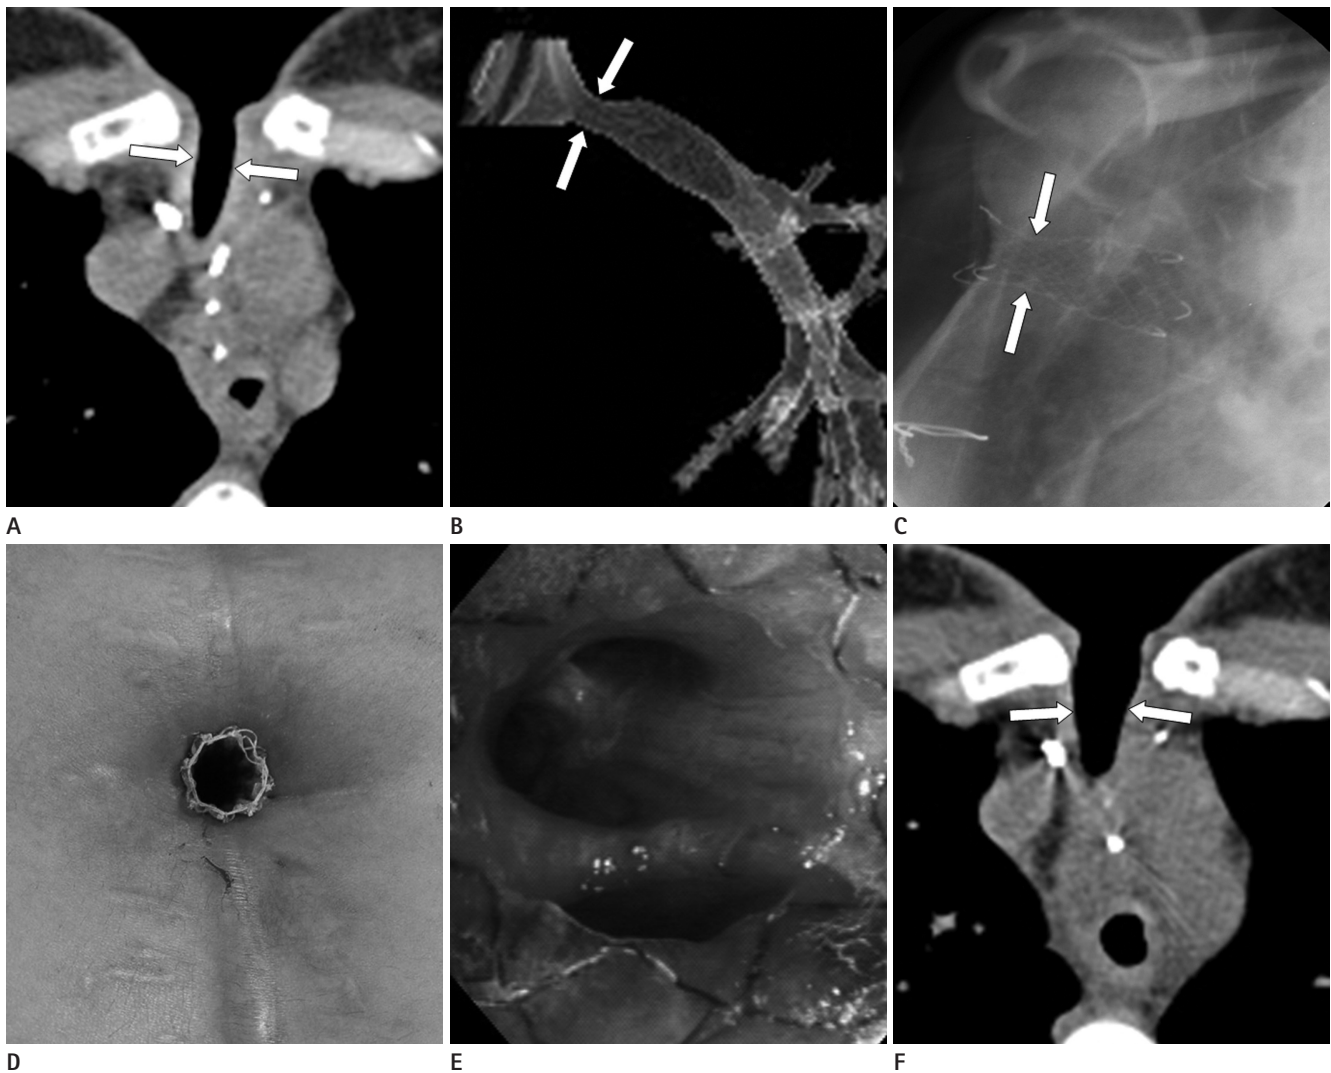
Temporary stent placement for the stricture of the stoma after anterior mediastinal tracheostomy for adenoid cystic carcinoma. A, B. Axial and reconstructed CT images show a tight stricture (arrows) at the ostium of the anterior mediastinal tracheostomy. C. A 12-mm-diameter, 3 cm-long, covered retrievable self-expandable nitinol stent was placed under fluoroscopic guidance to treat the stricture. There is a waist formation (arrows) of the stent at the stricture. D. The proximal end of the stent was exposed outside the skin. E. On bronchoscopy obtained after stent placement, the distal end of the stent lies at the carina level. F. A CT scan obtained after two months following the temporary stent placement, shows substantial widening of the previous stricture (arrows).
